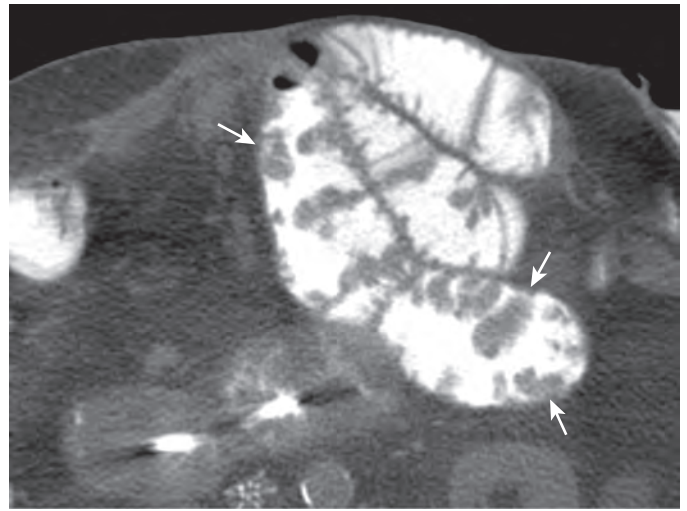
Familial adenomatous polyposis syndrome (FAPS). This CT scan from an enteroclysis performed with water-soluble contrast shows multiple polyps (arrows) within the jejunum.
